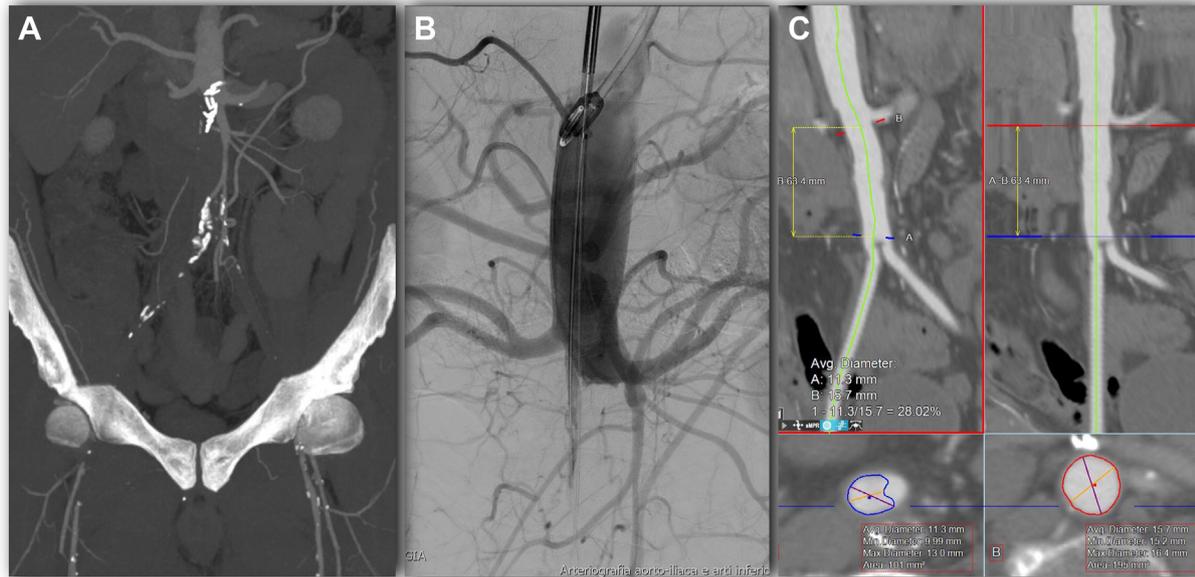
Preoperative computed tomography angiography (A) and intraoperative diagnostic angiography (B) showing patency of the paravisceral aorta and both renal arteries, with total occlusion starting from the native infrarenal aorta just below the left renal artery (LRA) and involving the entire previous aortobifemoral (ABF) bypass. Preoperative planning and centerline reconstruction were based on a previous computed tomography angiography scan demonstrating the length from the LRA to the flow divider (C).
